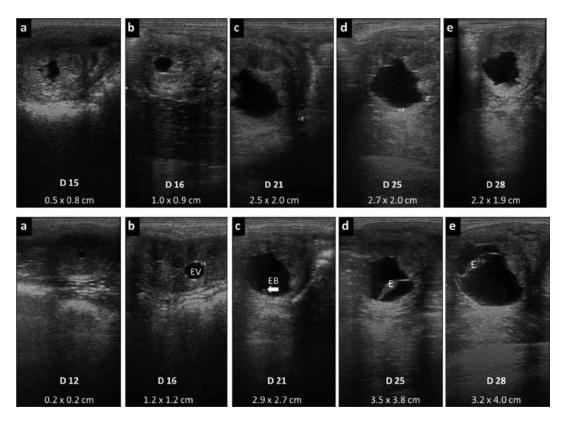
Ultrasound images of early embryonic death in mares. EV, Embryonic vesicle (upper panel); EB, Embryonic bud, and E, Embryonic mass (lower panel)
